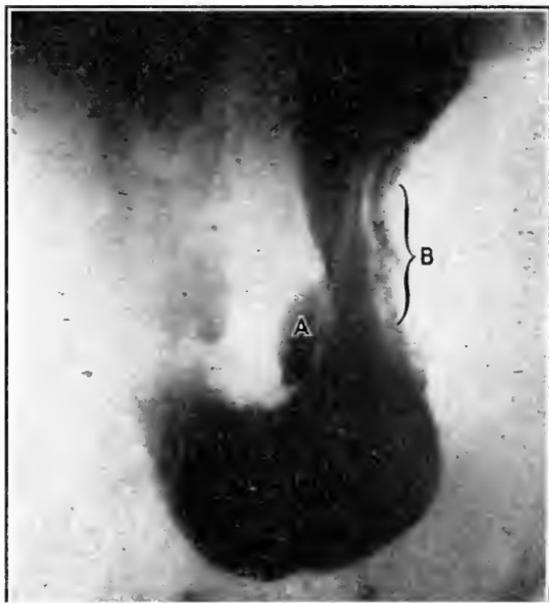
Penetrating ulcer on lesser curvature, showing crater, or “pocket,” filled with barium. Roentgen observation meal: A “positive” sign of ulcer of the stomach. (A, penetrating, greater curve ulcer, with accessory “niche”); B, area of muscle spasm. (Original observation by author.)
